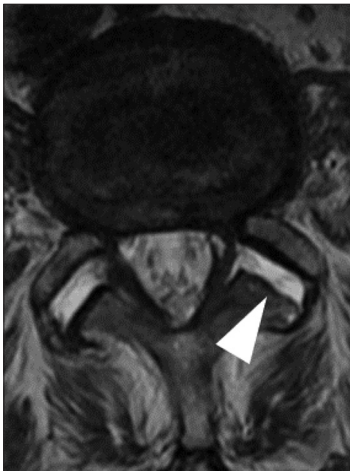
Facet fluid sign. Water intensity in facet on T2-weighted magnetic resonance imaging was defined as facet fluid sign (white arrowhead).
